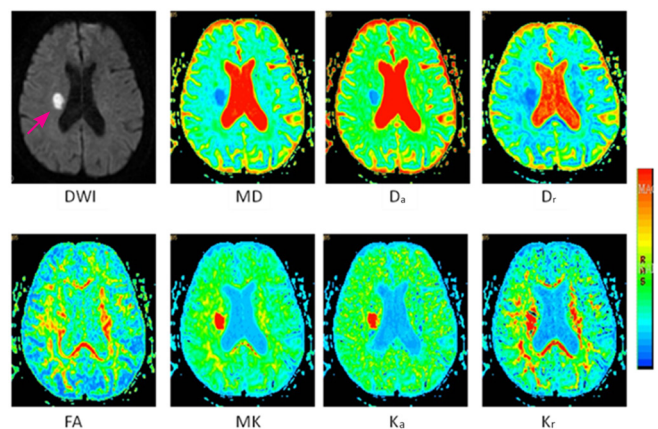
DKI-derived metric maps with lesion (pink arrow) located in periventricular white matter from a 73-year-old female patient suffering from an acute ischemic stroke (onset duration < 72 hours). Signal intensity of the lesion is decreased markedly on MD, D_a , and D_r maps, while it is increased on MK, K_a , and K_r maps. DWI: Diffusion weighted imaging; MD: mean diffusivity; D_a : axial diffusivity; D_r : radial diffusivity; FA: fractional anisotropy; MK: mean kurtosis; K_a : axial kurtosis; K_r : radial kurtosis; DKI: diffusion kurtosis imaging.
